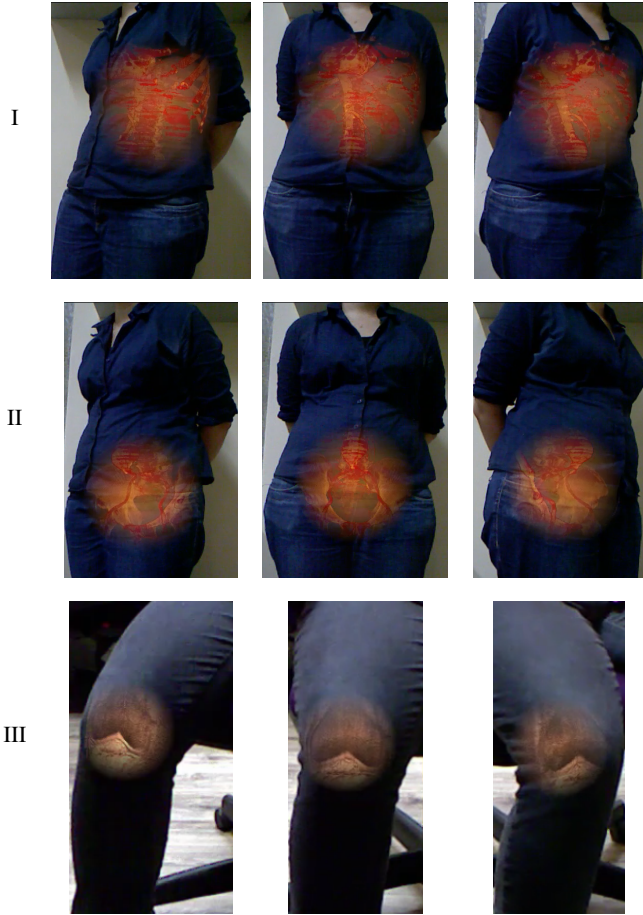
On-patient visualization of CT torso (rows I and II) and MRI knee (row III) datasets. To highlight the features of the CT torso dataset, we show the abdomen (row I) and pelvis (row II) separately.
